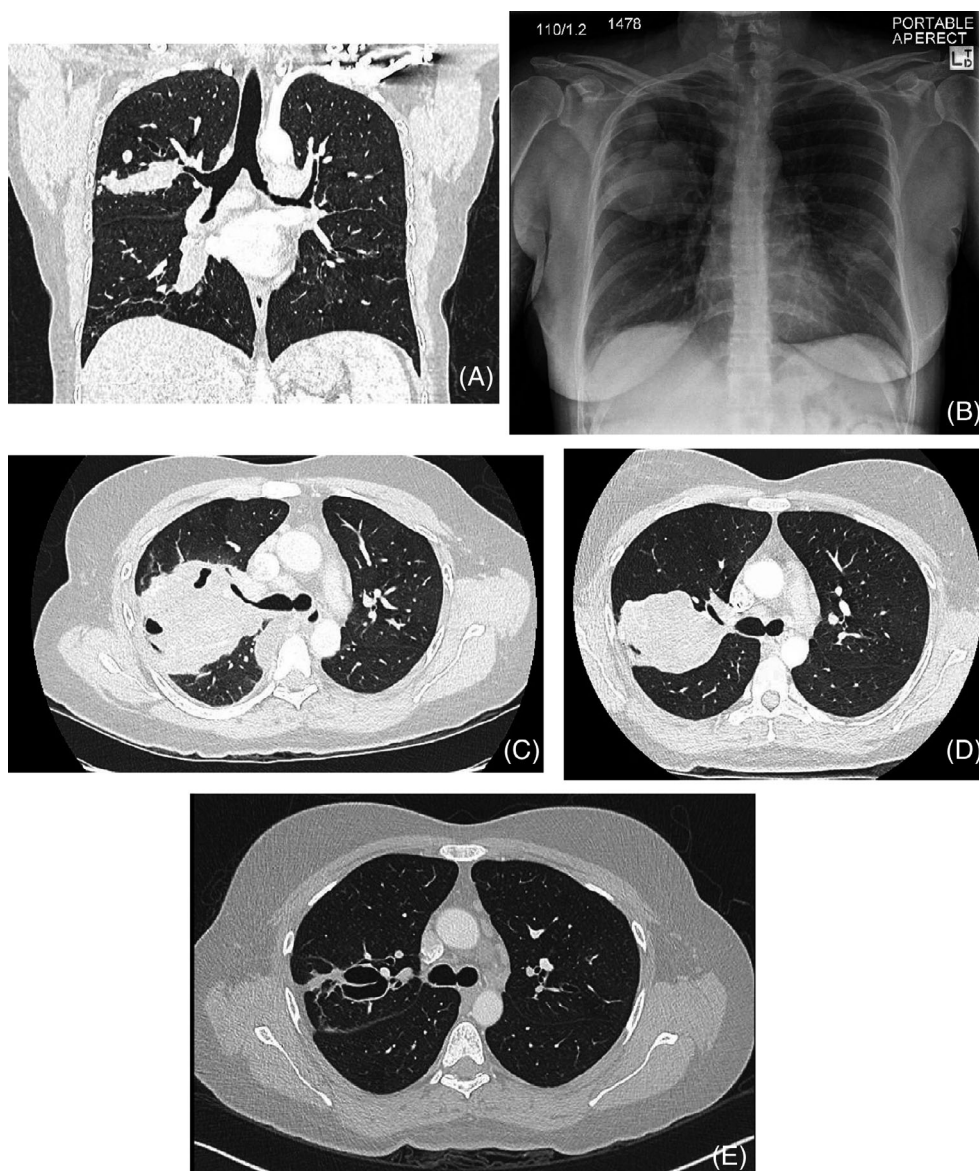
(A) Chest computed tomography (CT) scan. Presence of pre-existing bronchocele in the right upper lobe 4 years prior to hospital presentation. (B) Frontal chest radiograph performed at the time of initial presentation demonstrating worsening of the right upper lobe opacity and existing bronchocele following recent tooth extraction and probiotic use. (C–E) Serial chest CT (axial imaging—lung windows). (C) Worsening of the impacted bronchocele at the time of initial presentation following tooth extraction and probiotic use. (D) Further progression of the impacted bronchocele post-outpatient bronchoscopy. (E) Resolution of the impacted bronchocele 12 months following hospitalization
